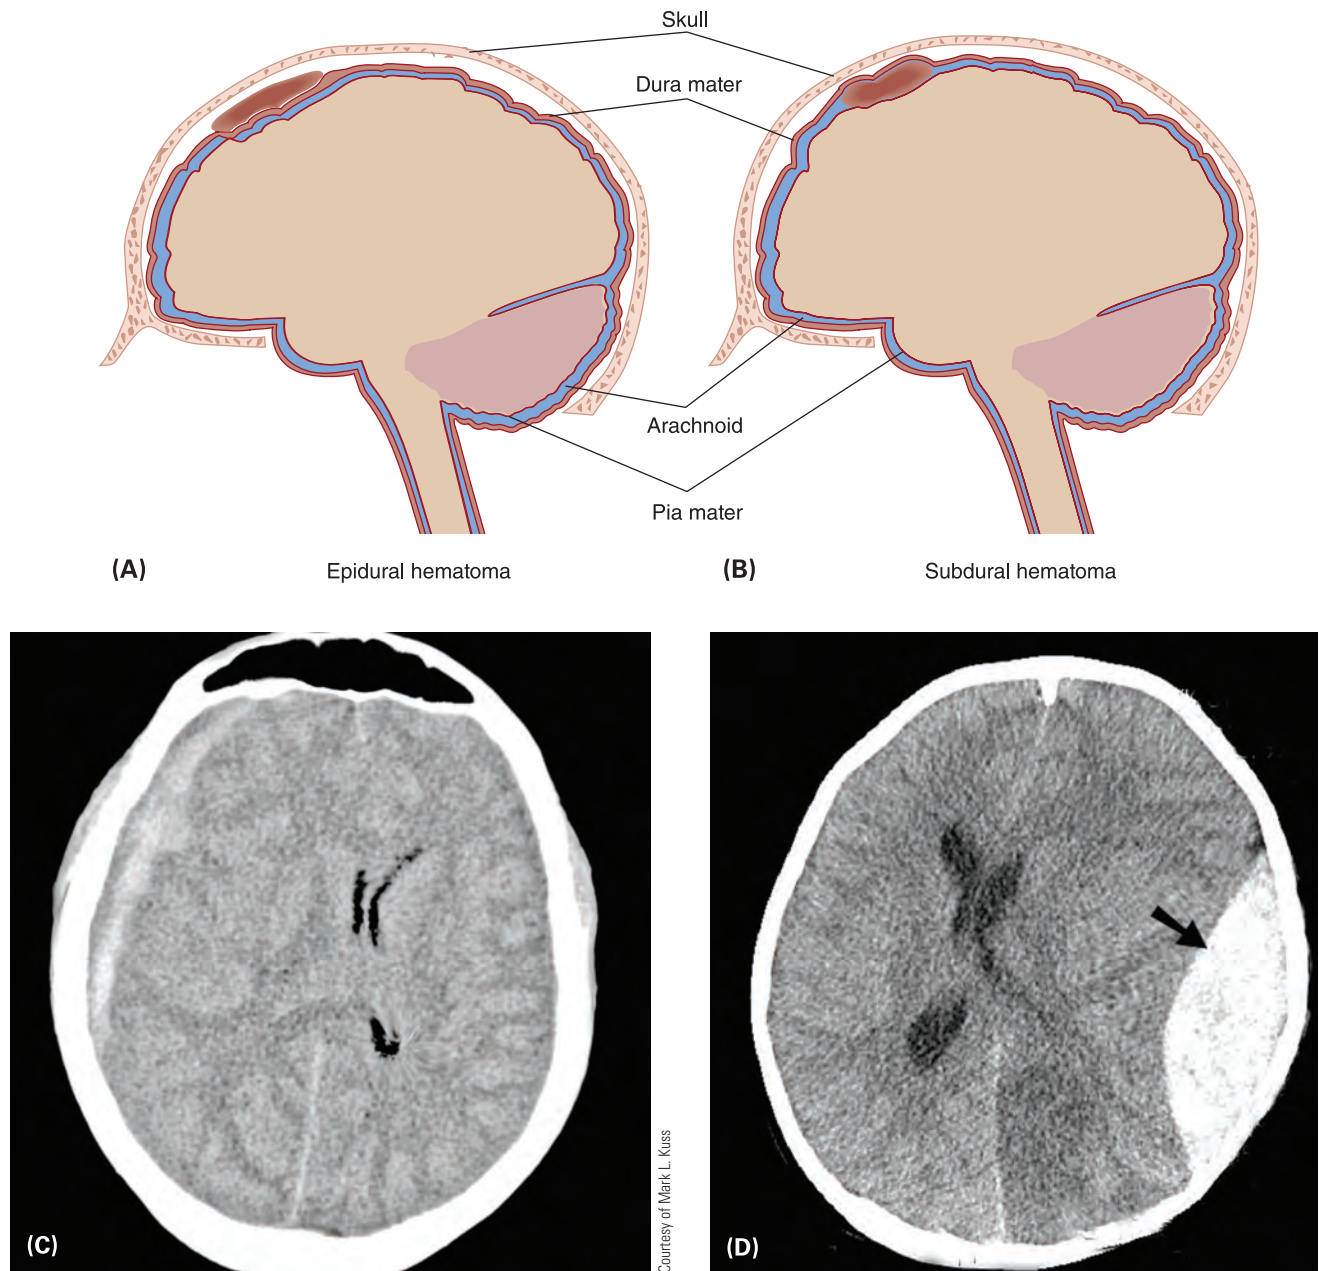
(A) Epidural and (B) subdural hematomas. (C) CT of epidural hematoma. (D) CT of subdural hematoma.
